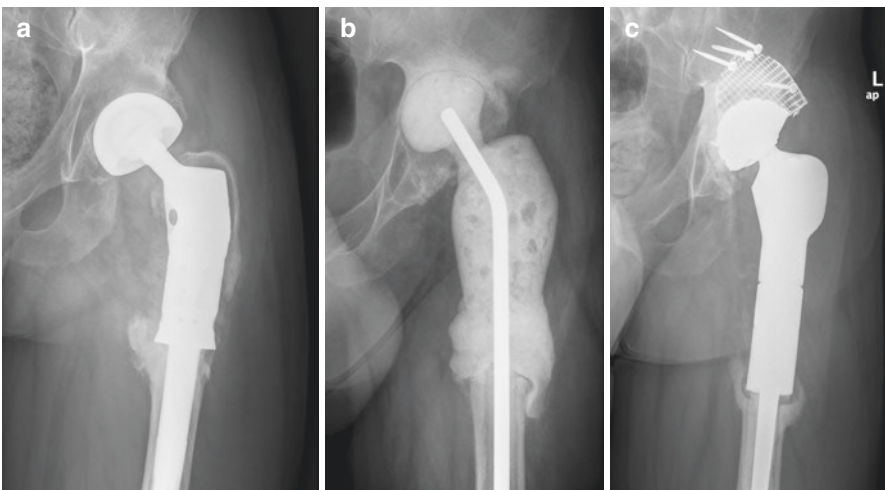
(a) Radiograph shows an infected bipolar tumoral femoral stem. (b) The prosthesis was removed and a spacer implanted. (c) A new femoral stem was implanted associated with a cup using impacting bone grafting technique
